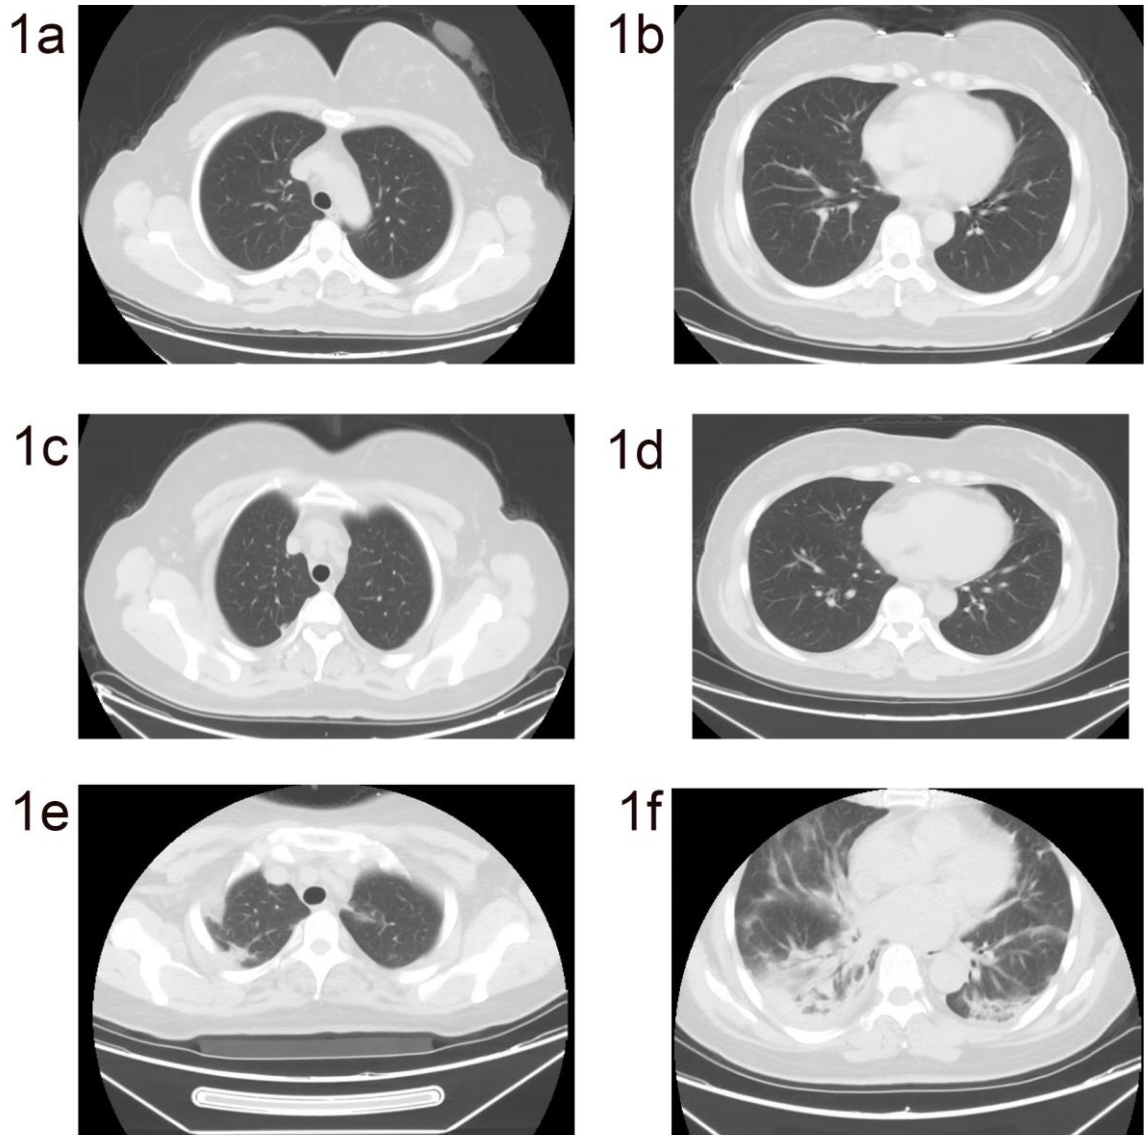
and Fig 1d: February 5th patient has a fever after a day of fatigue, with body temperature of 38 degrees, urgent examination of throat swabs and positive SARS-CoV-2 test, CT examination showed a few patchy shadows of the right upper lung;
